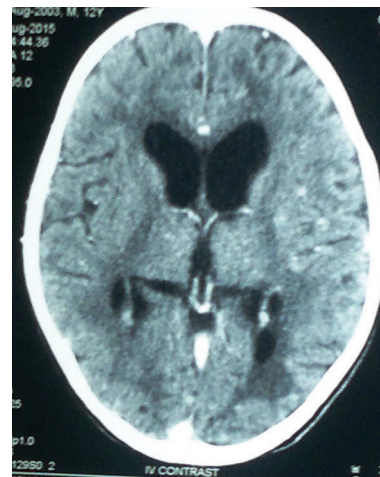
Repeat CT brain after treatment showing only few remnant calcified lesion.
